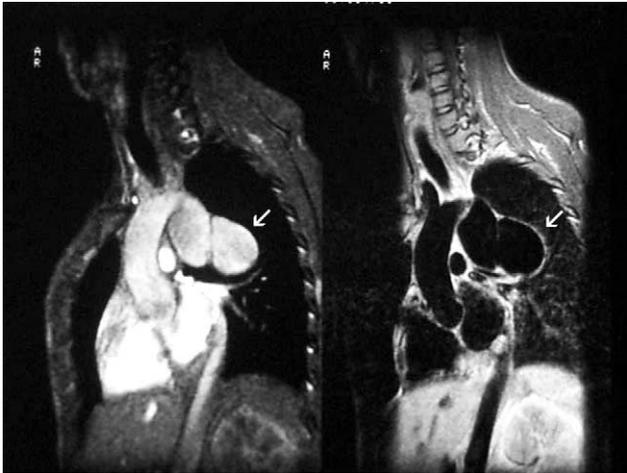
MRI parasagittal gated images showing a saccular aneurysm (white arrow) at the aortic isthmus just distal to the left subclavian artery. (Left) In the cine-gradient echo (repetition time/echo time = 50/14) the image signal intensity in the aneurysm is homogeneous. (Right) SET1 (repetition time/echo time = 923/14) of the aorta.
